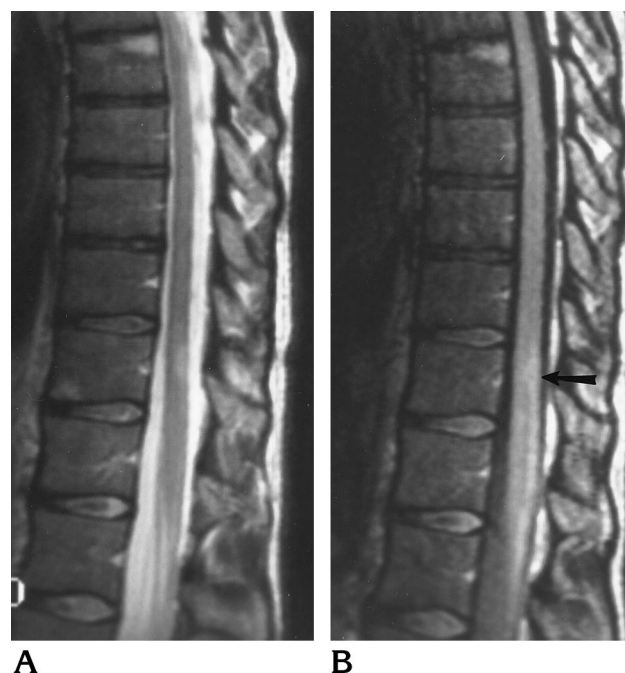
A 32-year-old woman with known MS lesions of the lower thoracic cord. Sagittal 3-mm fast spin-echo (2700/85/1) (A) and fast FLAIR (8000/102/1, TI of 2600) (B) images. The thoracic cord lesion is well seen on the conventional T2-weighted image, whereas only a suggestion of abnormal signal is seen on the FLAIR image in this location (arrow).
